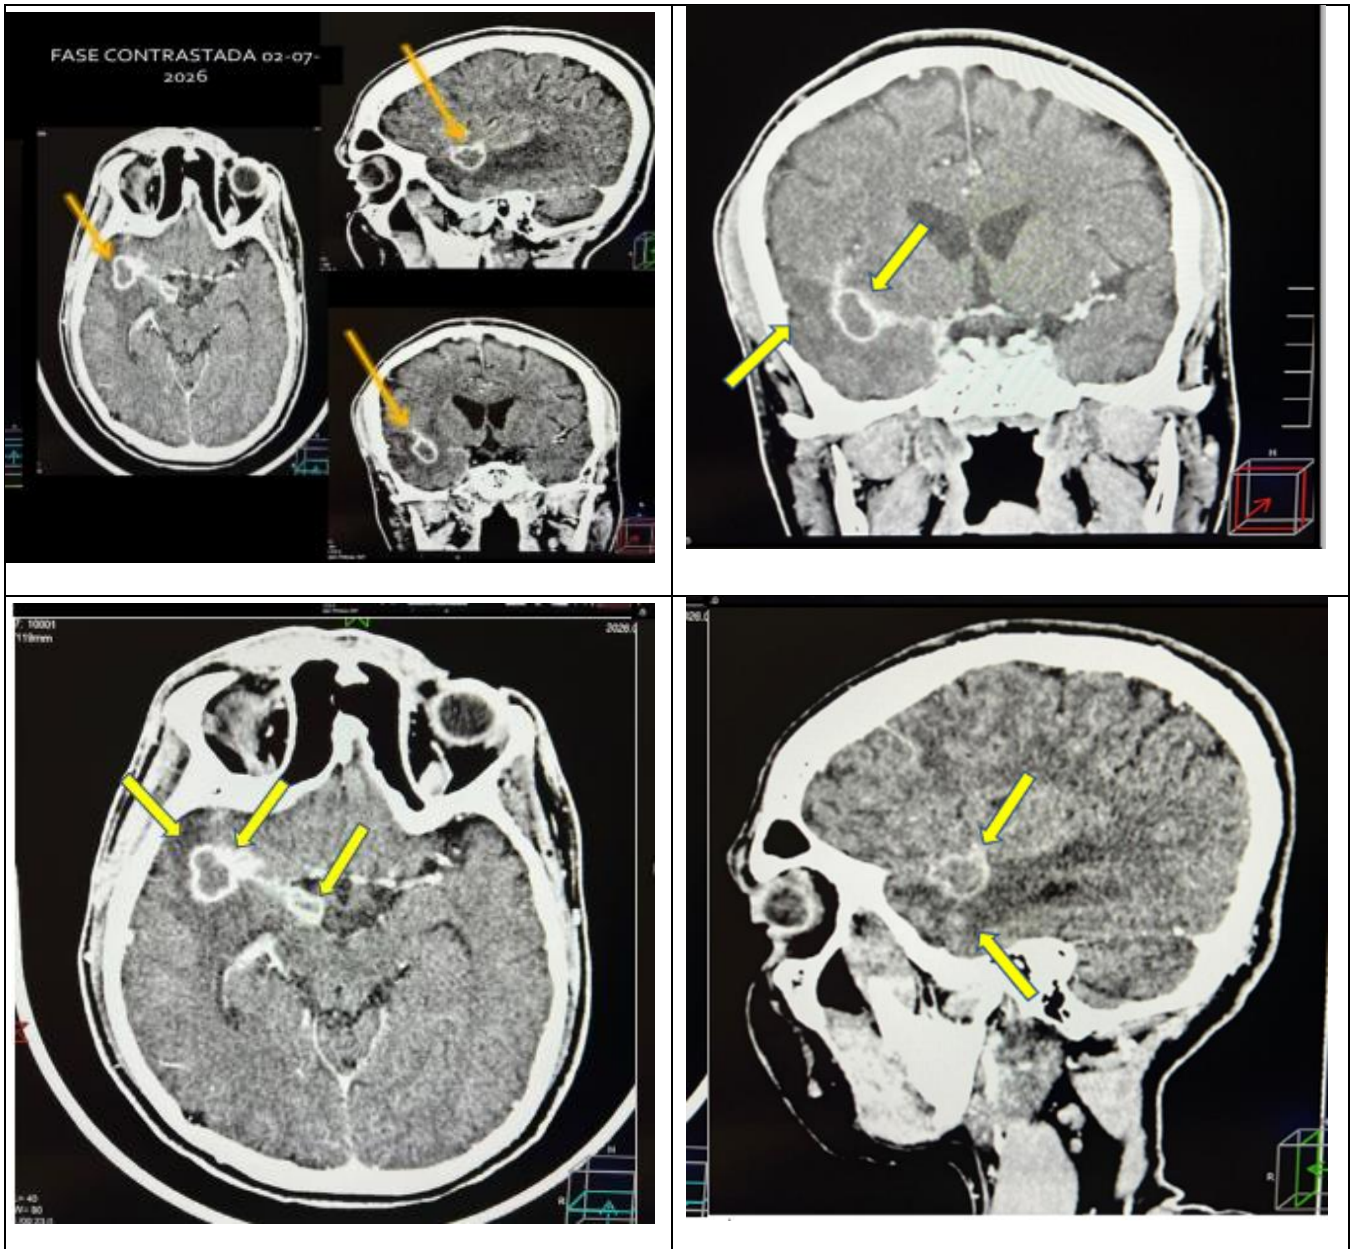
Contrast-enhanced CT scans in various sections showing a cerebral tuberculoma with perilesional edema (yellow arrows)
